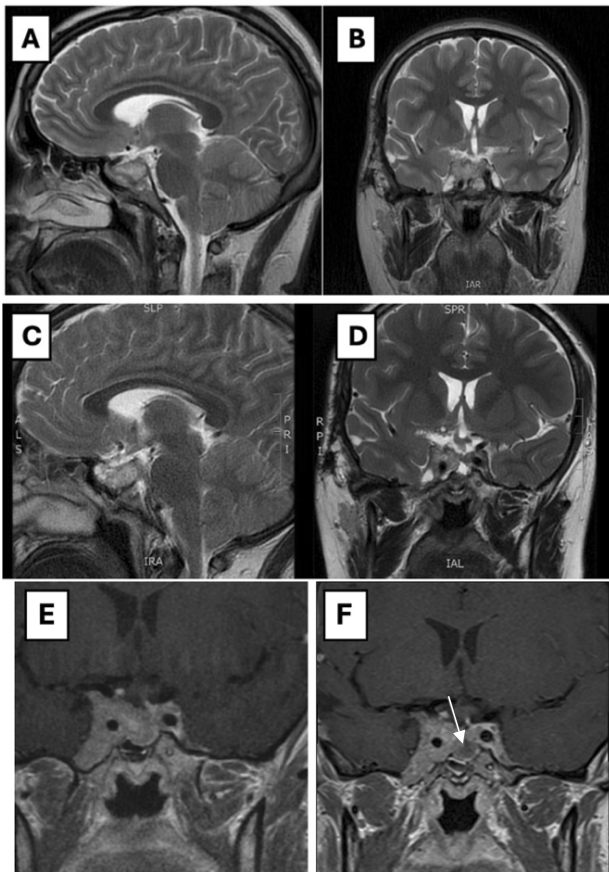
A, B. Sagittal T2 (A) and coronal T2 (B) magnetic resonance imaging (MRI) (July 2022) showing pituitary tumour ($38 \times 34 \times 33$ mm) infiltrating the right cavernous sinus and right optic nerve; C, D. Sagittal T2 (C) and coronal T2 (D) MRI (July 2023) showing stable dimensions of the tumour after pasireotide implementation; E, F. Coronal T1 MRI (July 2022) and coronal T1 MRI (July 2024) comparing the part of the tumour without (E) and with (F) a cystic degeneration of the tumour (arrow)
